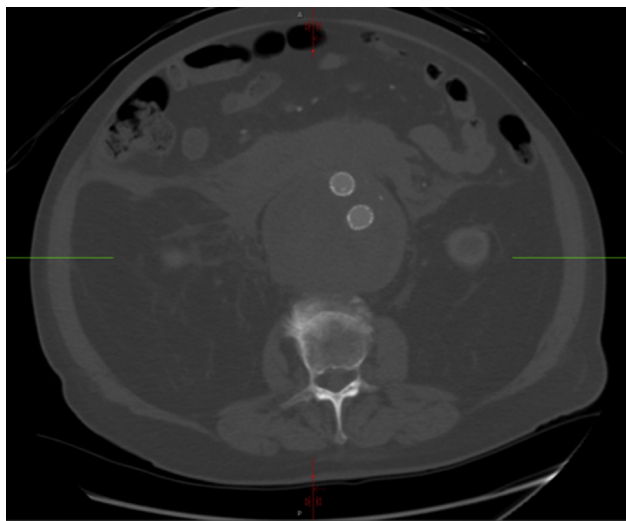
Preoperative computed tomography scan demonstrating a large hematoma.
